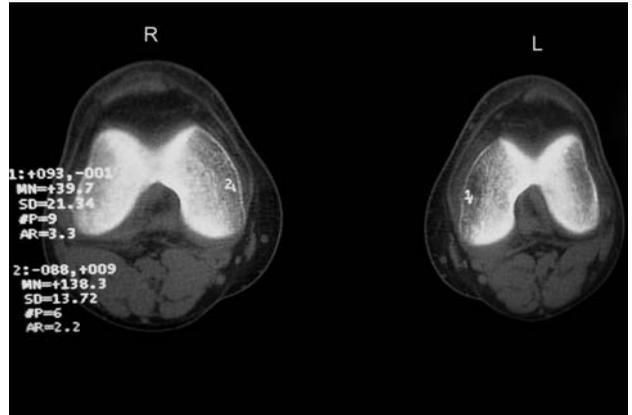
Transverse CT images showing relative osteopenia of the medial femoral condyle in the left knee.
